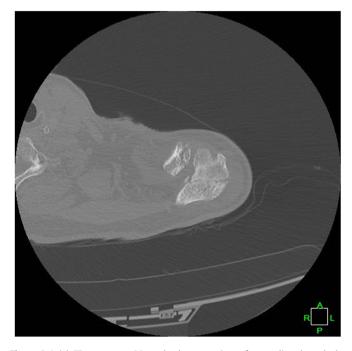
Axial CT scan cut at 20 weeks demonstrating a fracture line through the acromion. *CT*, computed tomography.
